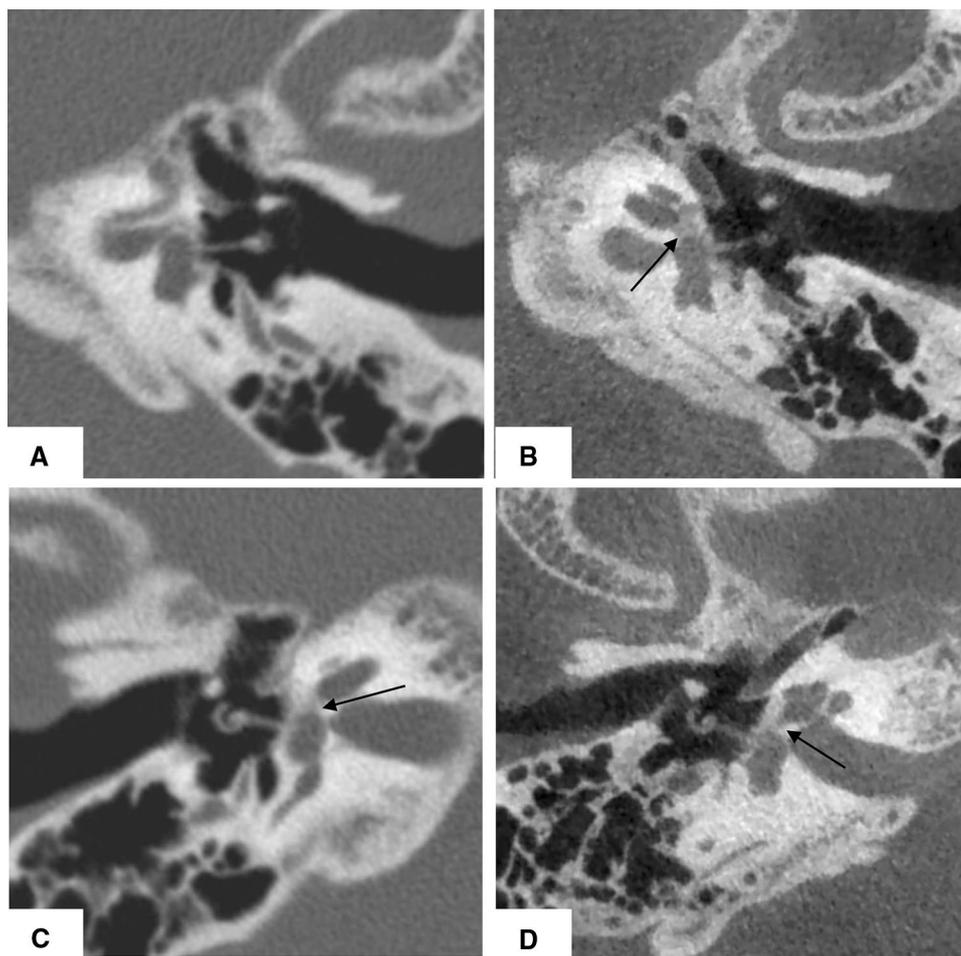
Lysis of the long process of incus (arrows). a MDCT, b CBCT: left temporal bone, axial cut. c MDCT, d CBCT: 3D reconstruction
